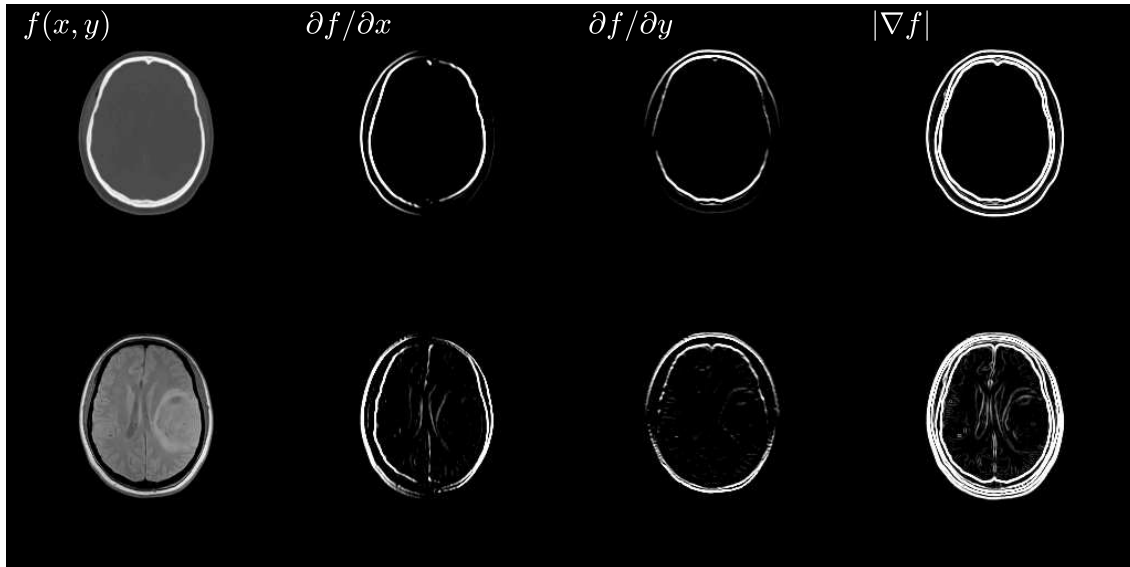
Gradient transform of an head image with CT on top row and MRI on bottom row. From left to right: original image, gradient in x direction, gradient in y direction, and gradient norm.
